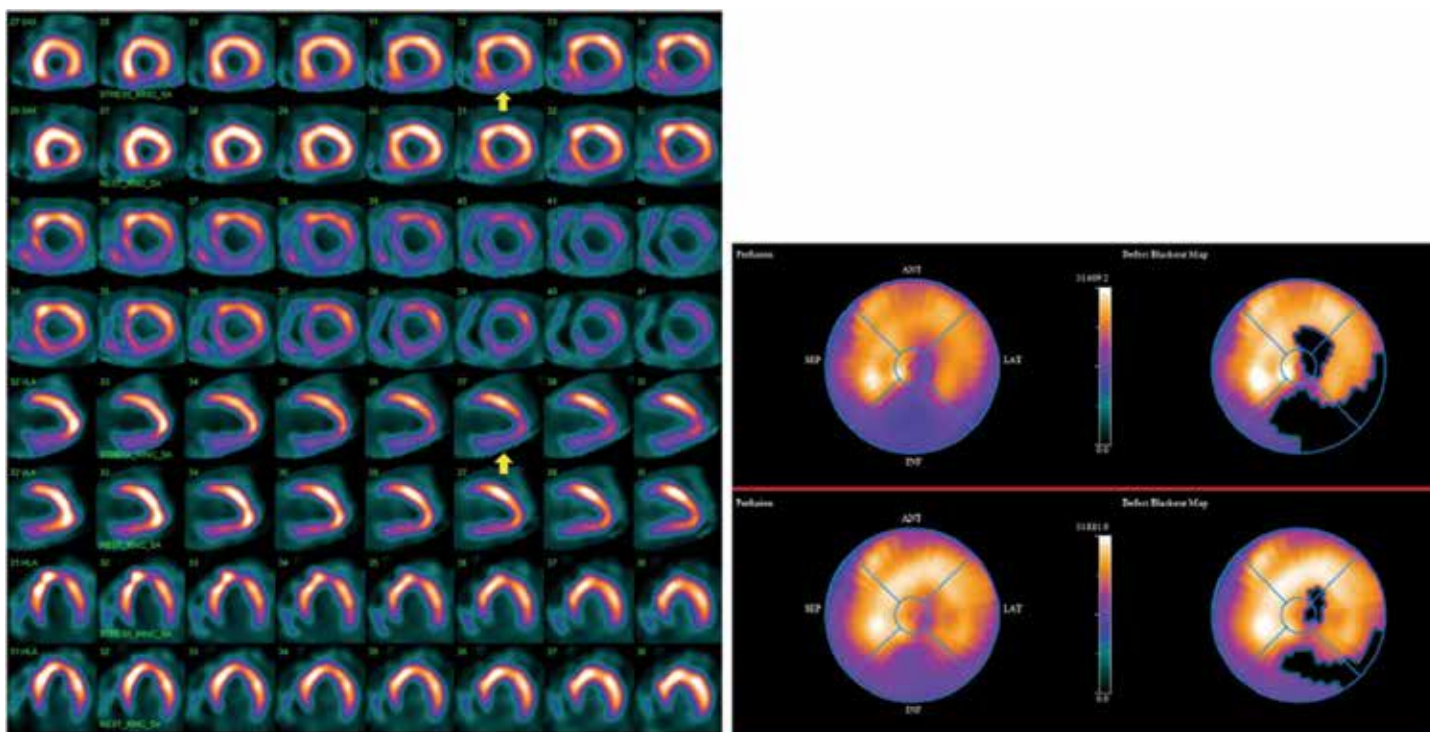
Left panel:* Stress/rest SPECT myocardial perfusion images (Tc-99m Sestamibi). There is a large area of mild partially reversible perfusion abnormality in the distribution of the left circumflex and right coronary arteries involving 25% of left ventricular myocardium (yellow arrow). There is no transient ischemic dilation, but there is severe fixed left ventricular dilation. *Right panel:* Raw and normalized polar maps at stress (upper row) and rest (lower row). The blackened areas represent perfusion defects.
